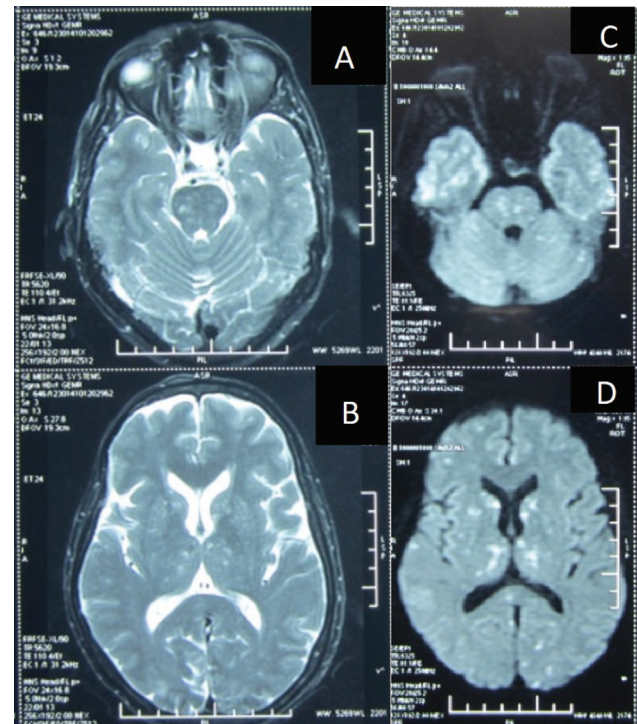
(A) Magnetic resonance imaging brain axial image, T2-weighted, showing multiple areas of hyperintensities in the cerebellum and the brainstem, corresponding to the diffusion restriction in the diffusion-weighted imaging (DWI). (B) Magnetic resonance imaging brain axial image, T2-weighted, showing multiple areas of hyperintensities in the subcortical white matter, corresponding to the diffusion restriction in the DWI. (C) Magnetic resonance imaging brain axial image, diffusion-weighted sequence, showing multiple punctate areas of diffusion restriction in the cerebellum and brainstem. (D) Magnetic resonance imaging brain axial image, diffusion-weighted sequence, showing multiple punctate areas of diffusion restriction in the subcortical white matter, in a “starfield” pattern. The diffusion restriction is seen predominantly in the border zones and deep gray nuclei bilaterally.
